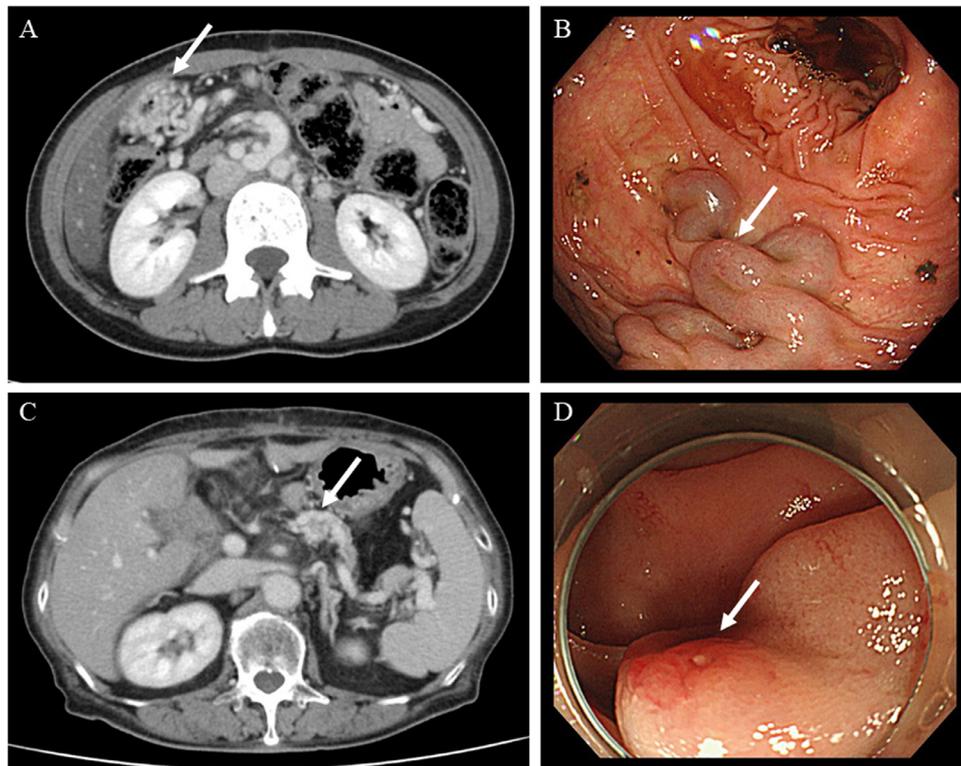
CT and endoscopic findings for patients with GI varices after pancreaticoduodenectomy. Representative images were shown for (A, B) the patient with varices at the hepatic flexure of the colon and (C, D) the patient with varices near the pancreaticojejunostomy.
